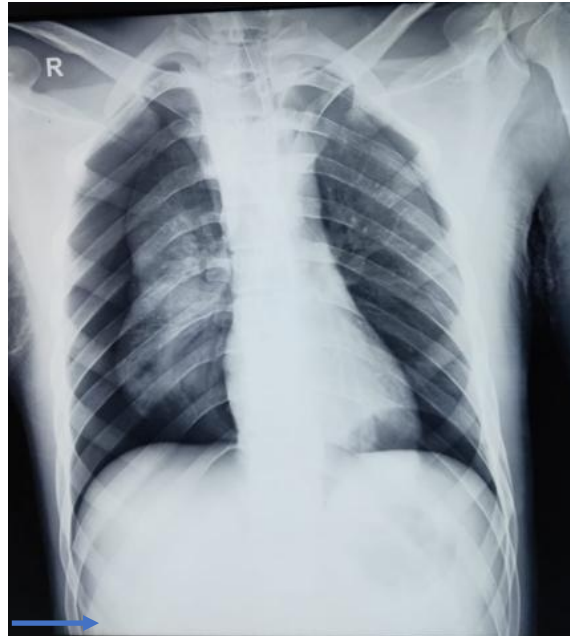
Chest Xray showed B/L pneumothorax
